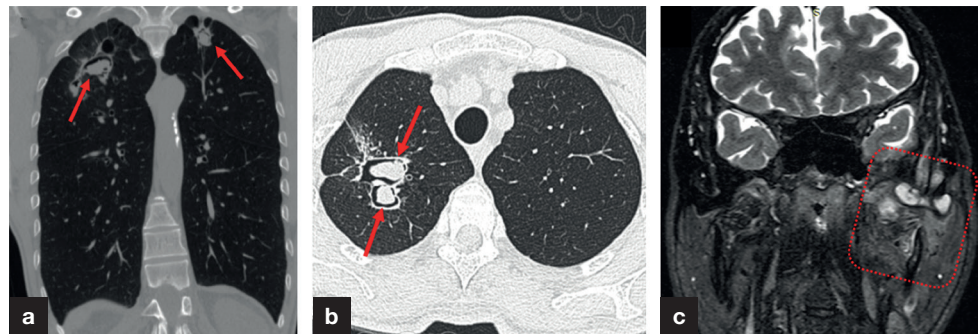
a. Coronal and (b) axial computed tomography scans in the parenchymal window show a few fungus balls associated with secondary aspergilloma within the tuberculosis cavities. c. Coronal T2 weighted magnetic resonance imaging revealed effusion in the left temporomandibular joint and increased signals in the periarticular areas. Magnetic resonance imaging findings are compatible with tuberculous arthritis.
